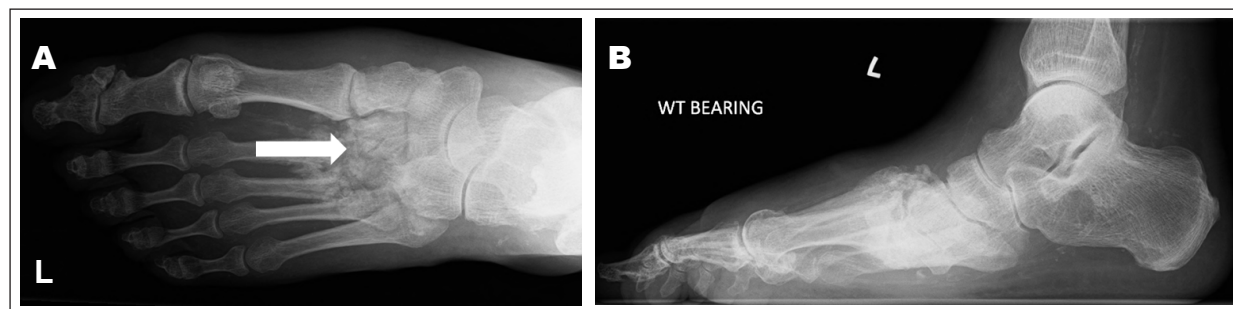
Left foot anteroposterior (A) and lateral (B) radiographs demonstrating midfoot collapse as well as widening of the first and second metatarsal interspace.
